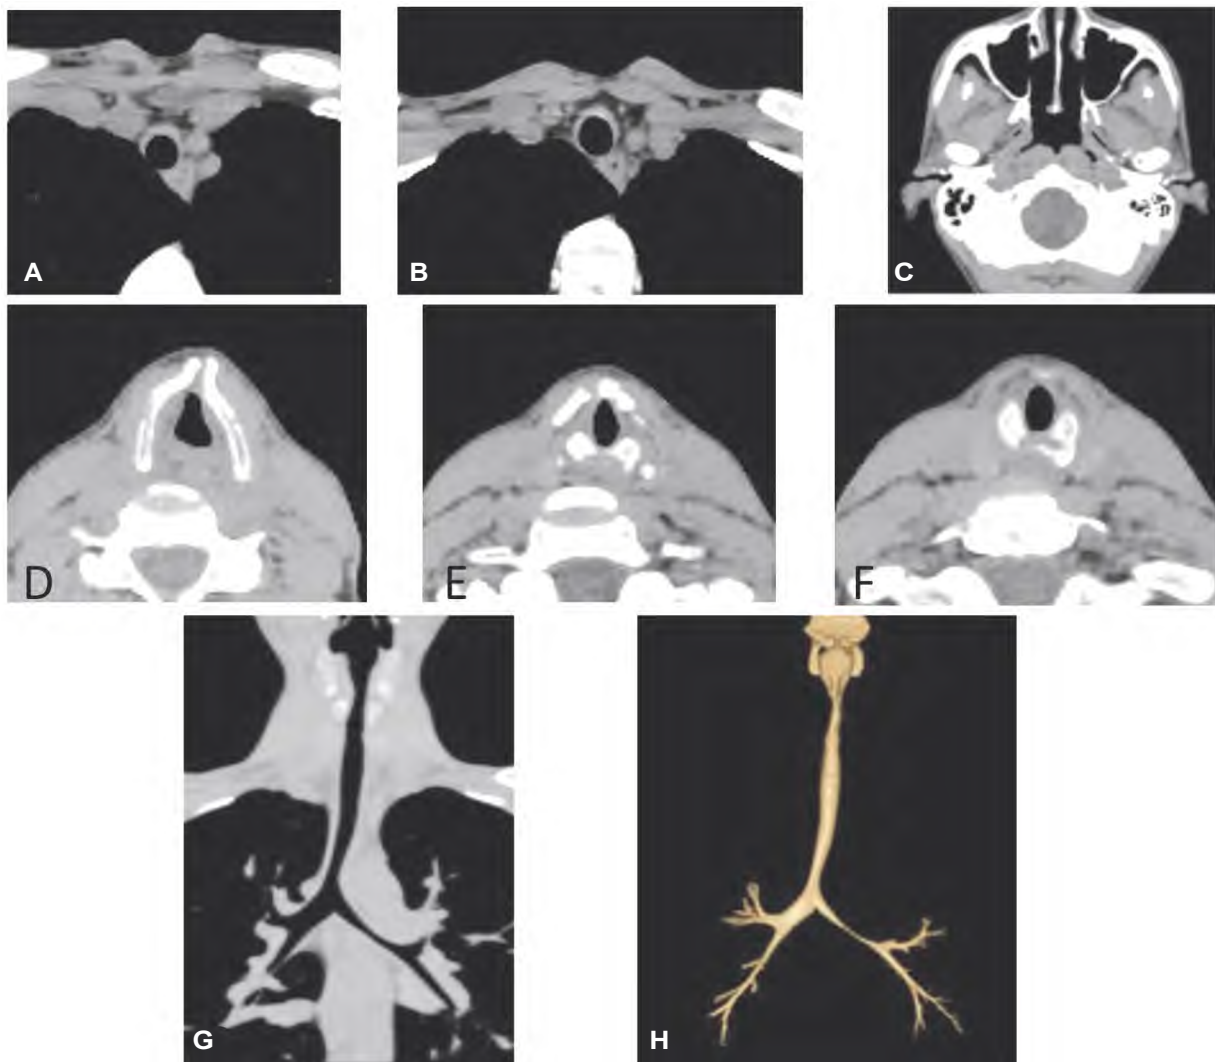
Diffuse tracheal and left main bronchus stenosis in a patient with relapsing polychondritis. (A, B) axial CT images of the trachea (C) axial CT images of the external auditory canal (D-F) axial CT images of the larynx (G, H) coronal reconstruction and 3D volume rendering of the tracheo-bronchial tree. Images demonstrate diffuse thickening of the cartilaginous portions of the trachea (anterior and lateral walls) sparing the posterior membranous wall with tiny foci of calcification within, irregular ossification and deformity of the laryngeal cartilages as well as mural thickening and calcification of the laryngeal portion of external auditory canals and Eustachian tubes.
